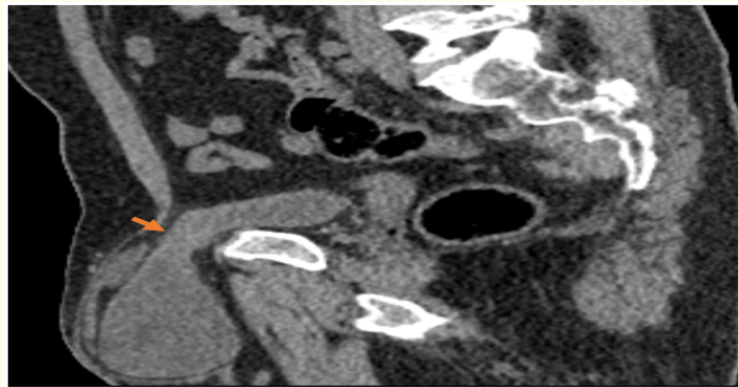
Contrast-enhanced sagittal CT reconstruction demonstrating right inguinal bladder herniation through a 15-mm fascial defect (Orange arrow), with protrusion of the urinary bladder into the right inguinal canal.
